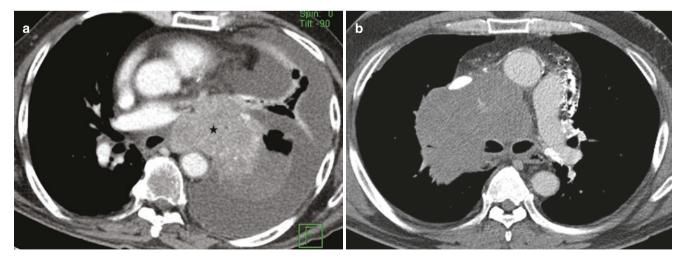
Small cell carcinoma in three patients. Left hilar nodal mass in first patient (a) Contrast-enhanced axial CT thorax in soft tissue window shows a large left hilar mass (asterisk) with collapse of left lower lobe and large left pleural effusion. Confluent nodal mass in second patient. (b, c) Axial and coronal CT images show large confluent nodal mass in the right hila and paramediastinal region with encasement of vessels and airways. Contiguous nodes in a third patient with small cell lung cancer. (d–g) Axial CT images show enlarged contiguous nodes in right supraclavicular region, right paratracheal region, prevascular space and subcarinal region
